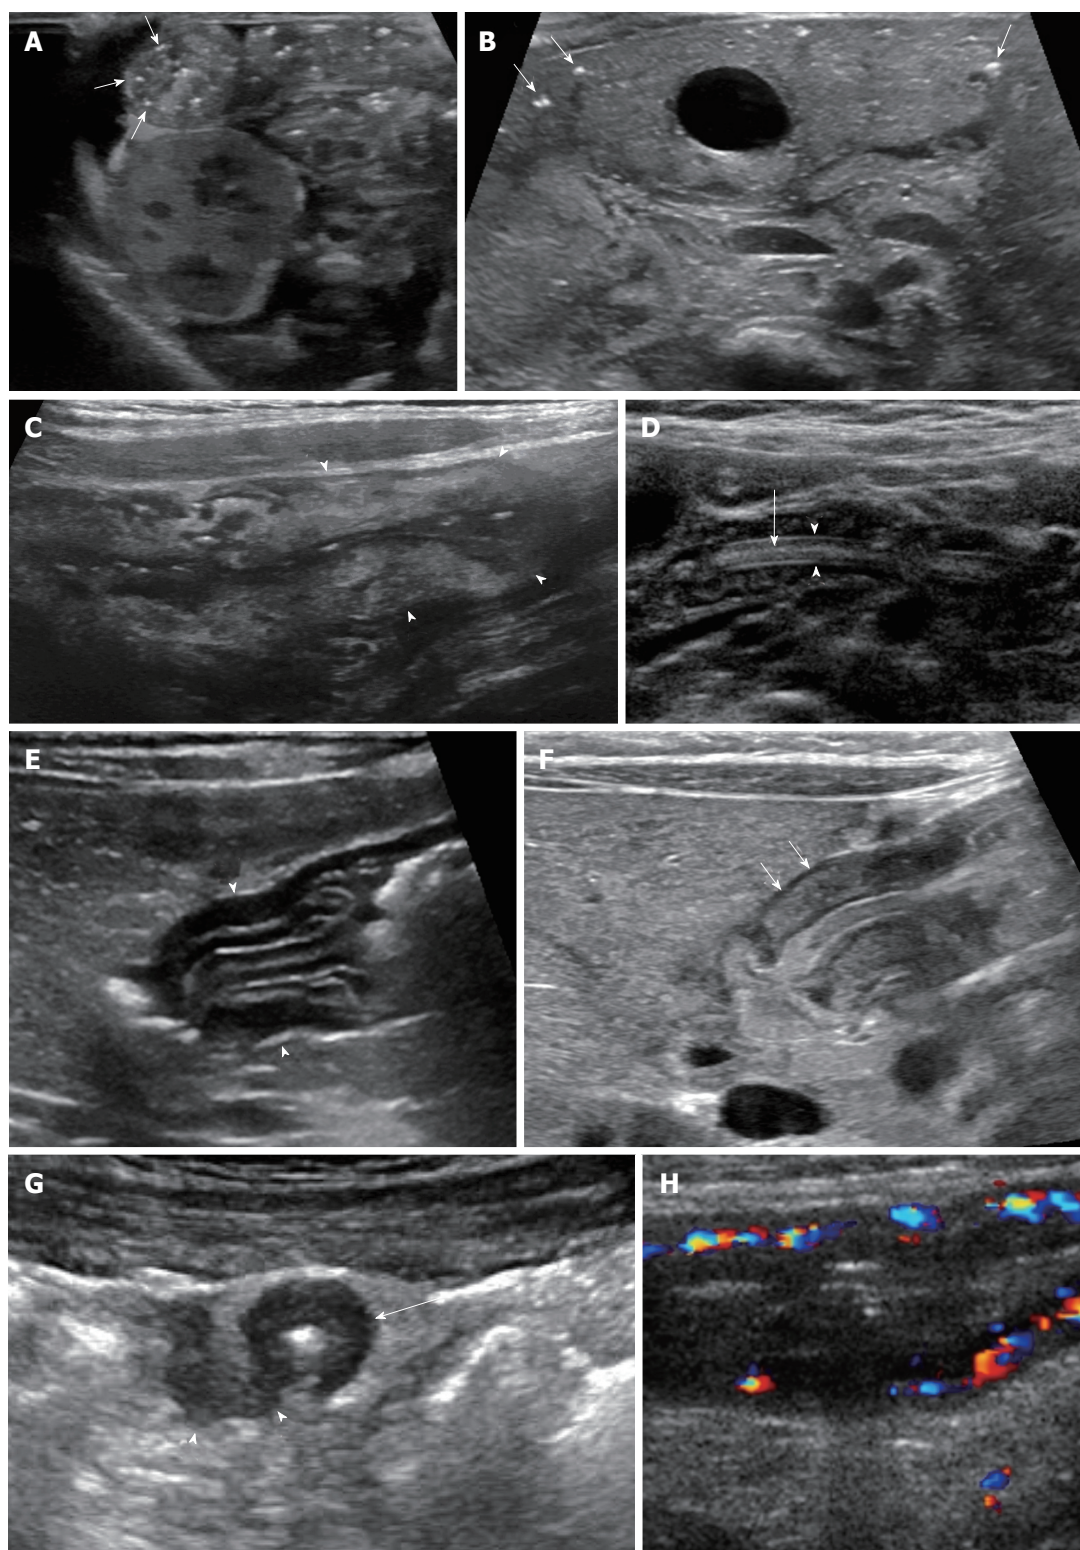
Infectious and inflammatory bowel disorders. A, B: Necrotizing enterocolitis. Targeted ultrasound of the abdomen in a premature infant shows bowel wall thickening and echogenic intramural air (A, arrows). This corresponded to an area of pneumatosis on recent radiograph (not shown). Transverse image of the liver show punctate, echogenic foci in the liver periphery, consistent with portal venous gas; the foci of air are too small to cause posterior artifact (B, arrows); C: *Campylobacter* enterocolitis. Ten-year-old with fever and abdominal pain with suspected appendicitis. Sagittal right lower quadrant ultrasound image shows mural thickening and increased echogenicity in the cecum and ascending colon (arrowheads). Stool cultures confirmed the diagnosis; D: Ascariasis. Two-year-old boy from Africa with abdominal pain. Ultrasound of the small bowel shows a mobile, hypoechoic, tubular structure with echogenic walls (arrowheads) and central linear echogenicity (arrow). Worms were later identified in the stool; E, F: Allergic (eosinophilic) gastritis. Ultrasound of the stomach in a 3-mo-old infant with persistent vomiting shows mural thickening in the antrum with prominent mucosal and submucosal layers (E, arrowheads). Endoscopy confirmed the diagnosis. Ultrasound of child with pyloric stenosis (F), for comparison, shows thickening primarily of the muscularis layer (arrows); G, H: Crohn disease. Transverse image of the right lower quadrant in a 15-year-old girl with longstanding Crohn disease shows a thick-walled ileum in cross section (arrow) with a fistula extending posterolaterally (arrowheads), confirmed with MRI (not shown) (G, arrows). Color Doppler ultrasound image in another patient with Crohn disease demonstrates mural thickening and hyperemia of the inflamed terminal ileum (H).
